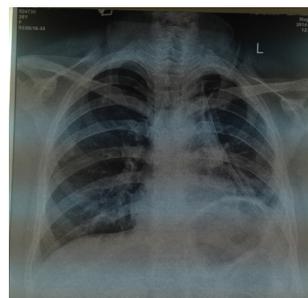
Chest X-ray after en bloc left upper lobe with thymus resection, which shows chest tube and left diaphragm elevation.
